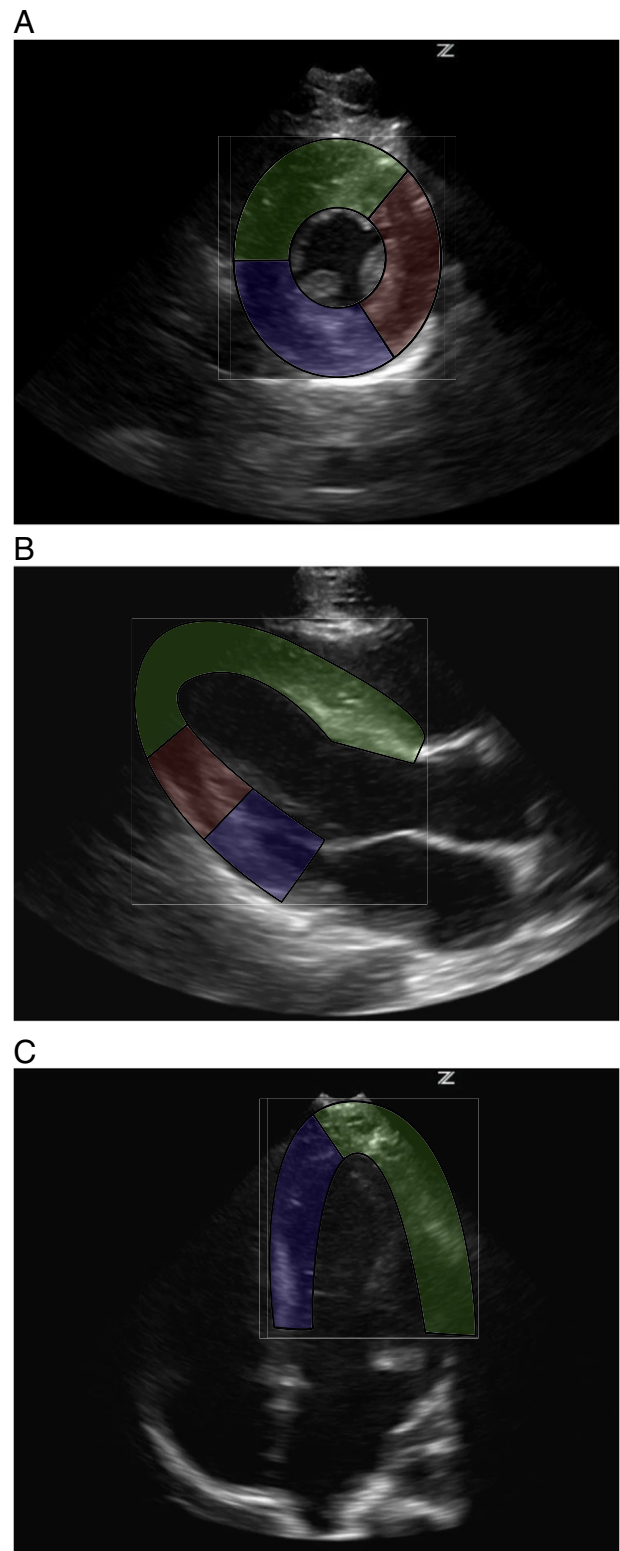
Simplified, color-coded map for localizing RWMA as seen on POC echocardiography in standard parasternal short-axis (A), parasternal long axis (B), and apical 4-chamber views (C). Green represents anterior, anterolateral, and anteroseptal segments; blue represents basal and inferior septal segments; and red represents anterolateral and inferolateral segments. Although there is significant individual variation in perfusion territory, with rough approximations, green roughly represents LAD artery distribution, red the circumflex distribution, and blue the right coronary artery distribution.
